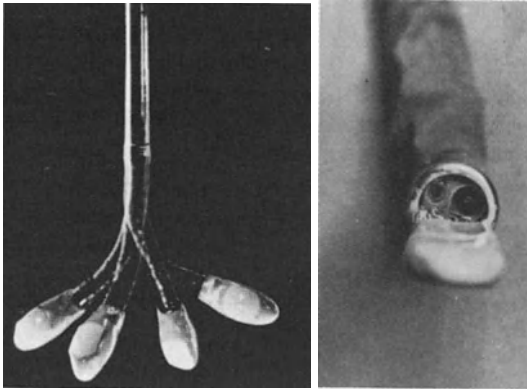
Two transesophageal phased array systems fitted on a gastroscope, one of them (*right*) with optic channels on a plate. (From [13])
